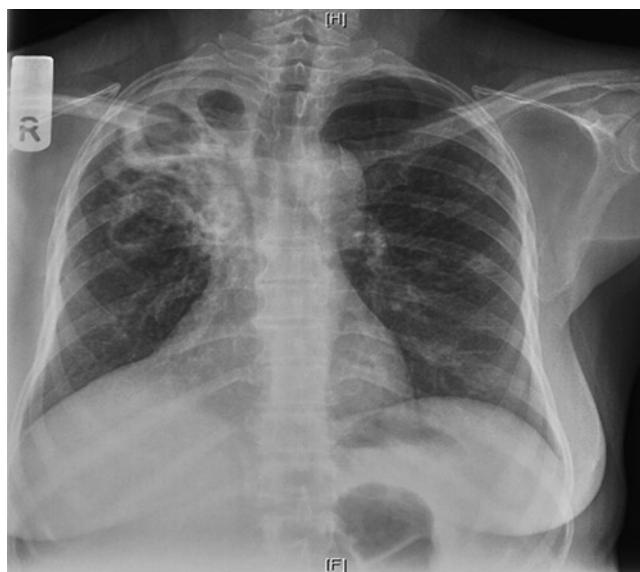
The chest X-ray of a patient with pulmonary tuberculosis demonstrating fibrosis and cavitation of the right upper lobe with loss of lung parenchyma and distortion of the trachea.
